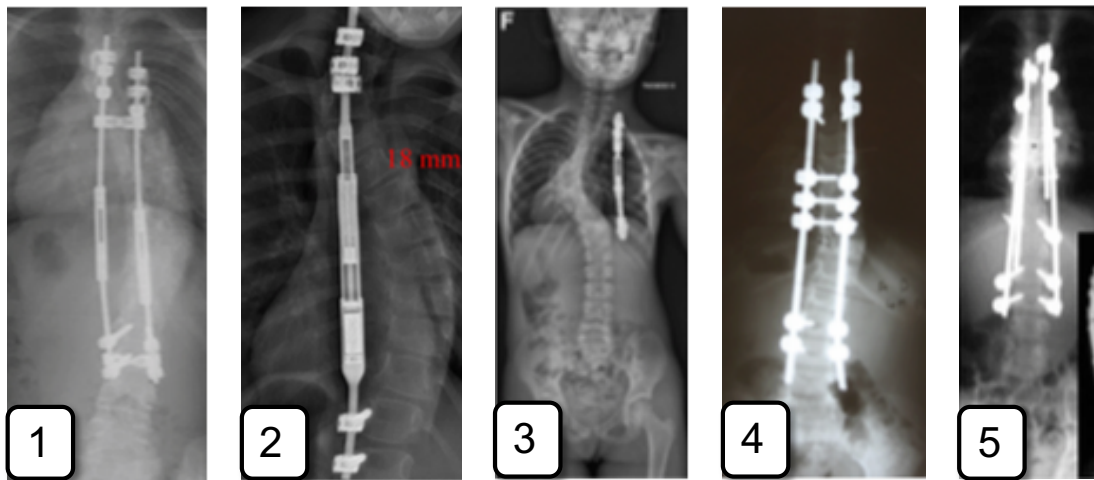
Radiographic examples of: 1- Growing rods, 2- Magnetic growing rod, 3- VEPTR, 4- Shilla, 5- modern Luque trolley (1 to 4 modified from [159], 5 modified from [163])
